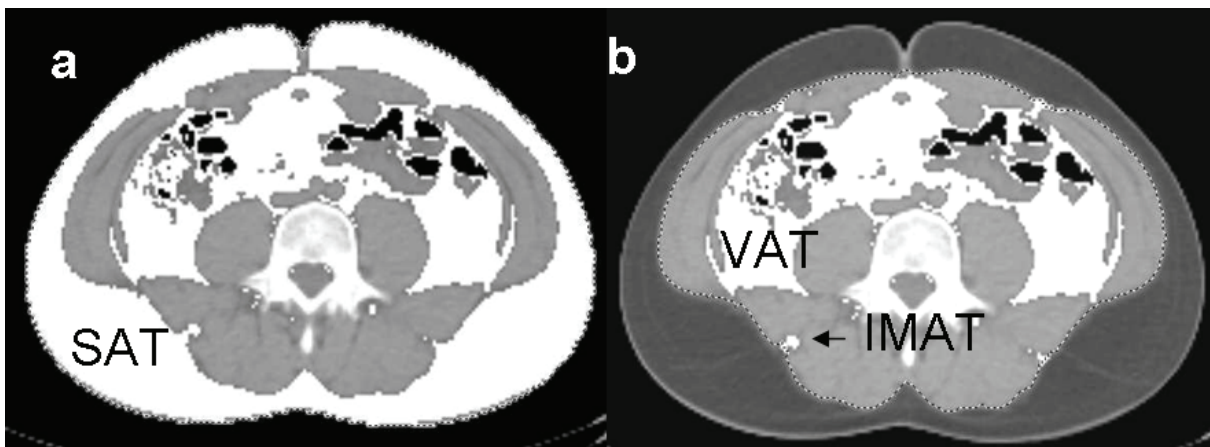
To assess the adipose tissue areas in the abdomen (position 11 in figure 7) all pixels categorized as adipose tissue, *i.e.* CT numbers from -190 to -30 HU, are marked (white) by the computer program as is shown in figure 3a. Figure 3b shows the semi-automatic delineation of the outer muscle border. When the area of the adipose tissue pixels in figure 3b, mainly visceral adipose tissue (VAT) and intramuscular adipose tissue (IMAT), is subtracted from the area of the pixels in figure 3a (all AT) the resulting area is the calculated subcutaneous adipose tissue (SAT) area.
